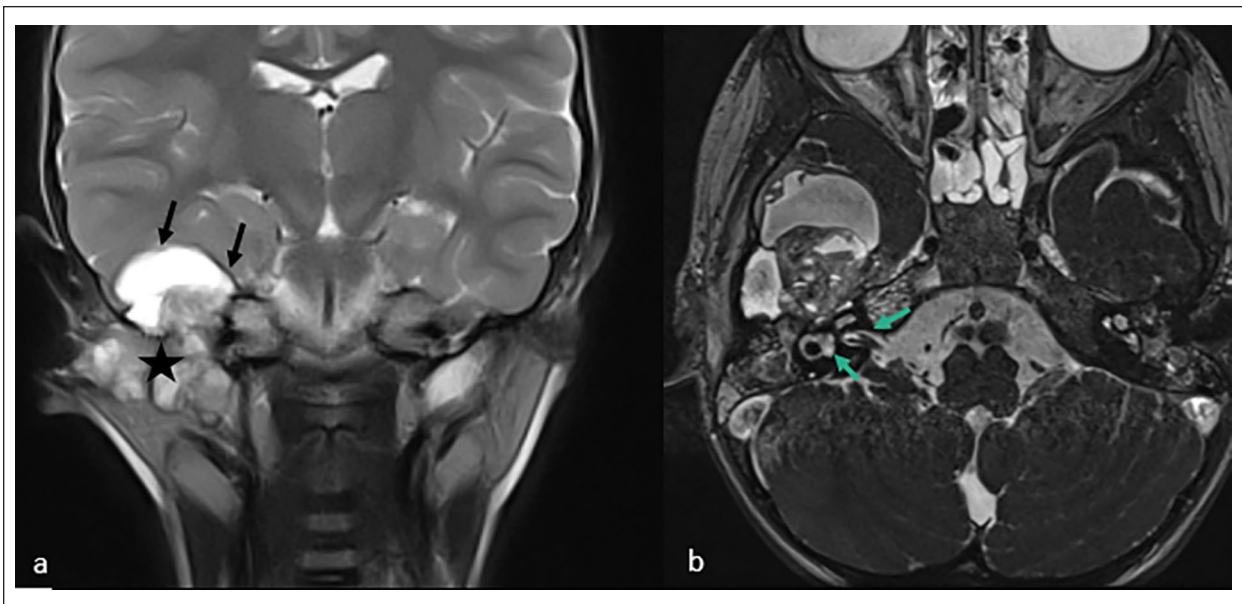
MR images at the time of presentation: coronal T2-weighted sequence (a) and axial steady-state gradient-echo sequence (b) showing the tumor (asterisk) with its intracranial extension (black arrows). The integrity of the inner ear and the internal auditory canal is noted (blue arrows).
